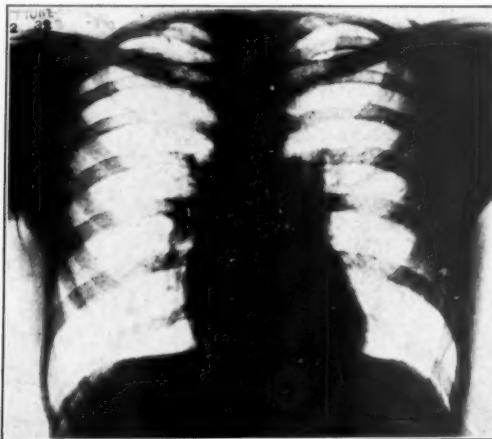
(Case 3) A roentgenogram of the chest obtained during the interval when the patient was free from symptoms. The heart shadow shows moderate rounding of the left ventricle and the lung fields are clear, with the exception of the hilar shadows which are accentuated.
